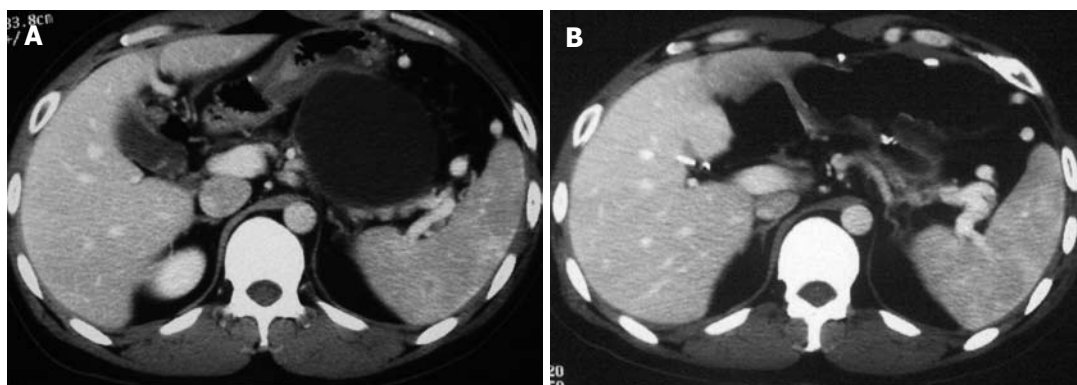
A: Pre-operative CT scan shows a 7.5 cm X 6.0 cm pseudocyst, is in close contact with the posterior wall of the stomach. In addition, splenic vein compression and splenomegaly are also observed. B: Post-operative CT scan reveals effective drainage of the pseudocyst and dramatic relief of splenic vein compression.
